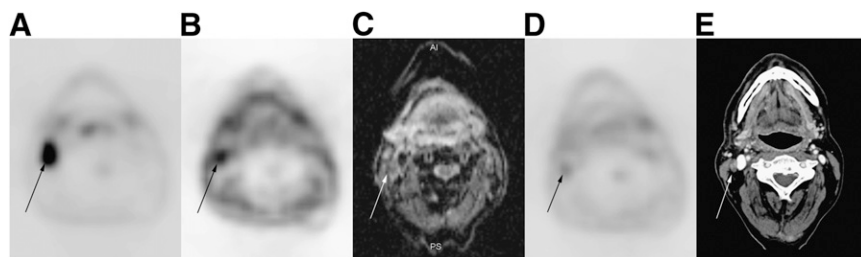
(A and B) Pretreatment ^{18}F -FDG PET showed metastatic adenopathy at level 2 (arrow) (A), which remained hypoxic on ^{18}F -fluoromisonidazole PET scan during RT treatment (week 4) (B). (C and D) This lymph node still had restricted apparent diffusion coefficient on DW MRI at 3 wk after end of radiotherapy (C) and remained suspect on ^{18}F -FDG PET at 8 wk after treatment (D). (E) Residual disease was confirmed in this node (patient 8).
